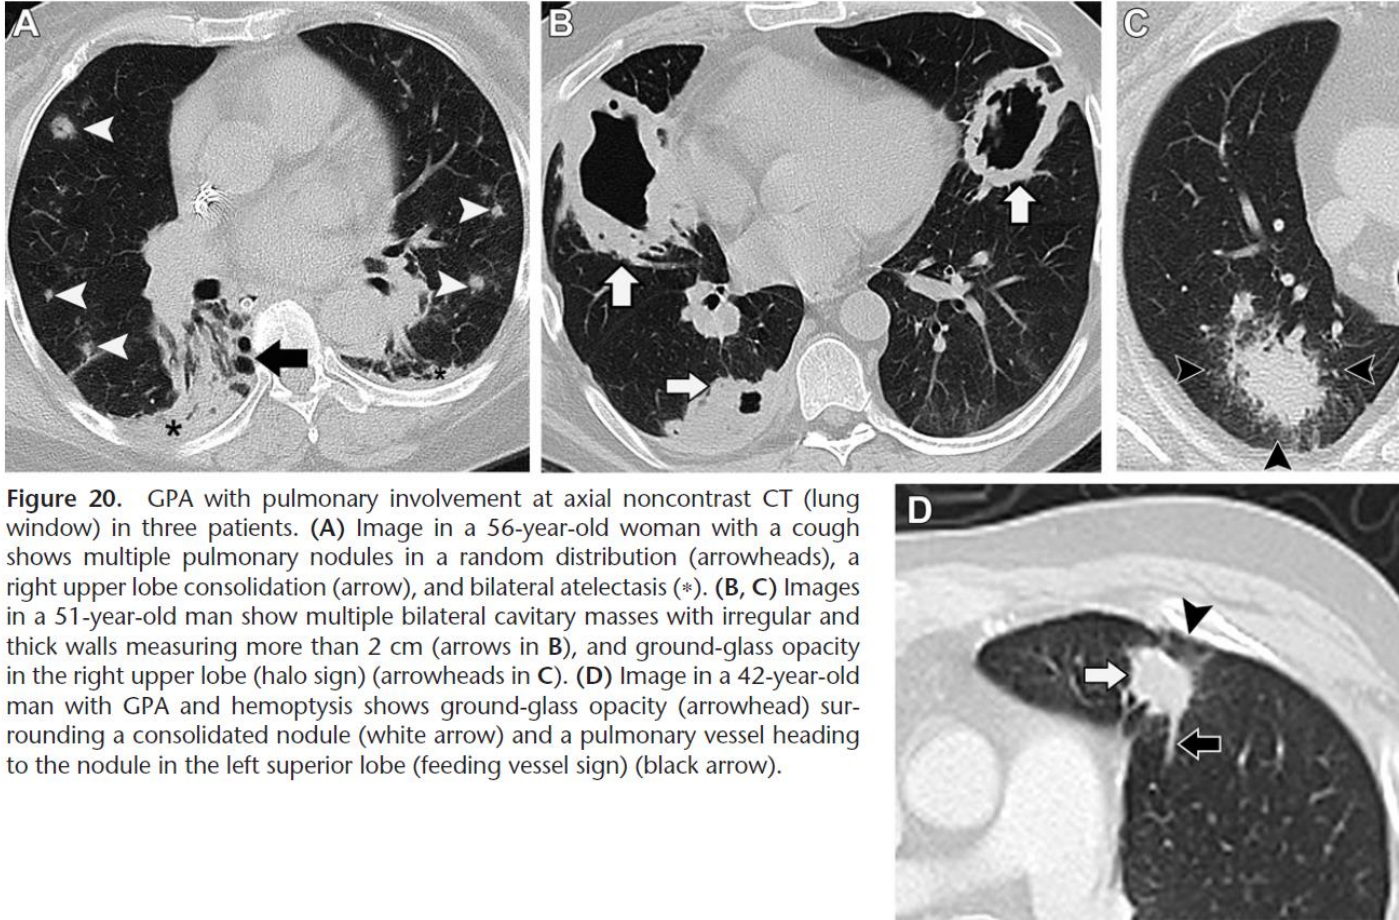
GPA with pulmonary involvement at axial noncontrast CT (lung window) in three patients. (A) Image in a 56-year-old woman with a cough shows multiple pulmonary nodules in a random distribution (arrowheads), a right upper lobe consolidation (arrow), and bilateral atelectasis (*). (B, C) Images in a 51-year-old man show multiple bilateral cavitary masses with irregular and thick walls measuring more than 2 cm (arrows in B), and ground-glass opacity in the right upper lobe (halo sign) (arrowheads in C). (D) Image in a 42-year-old man with GPA and hemoptysis shows ground-glass opacity (arrowhead) surrounding a consolidated nodule (white arrow) and a pulmonary vessel heading to the nodule in the left superior lobe (feeding vessel sign) (black arrow).
